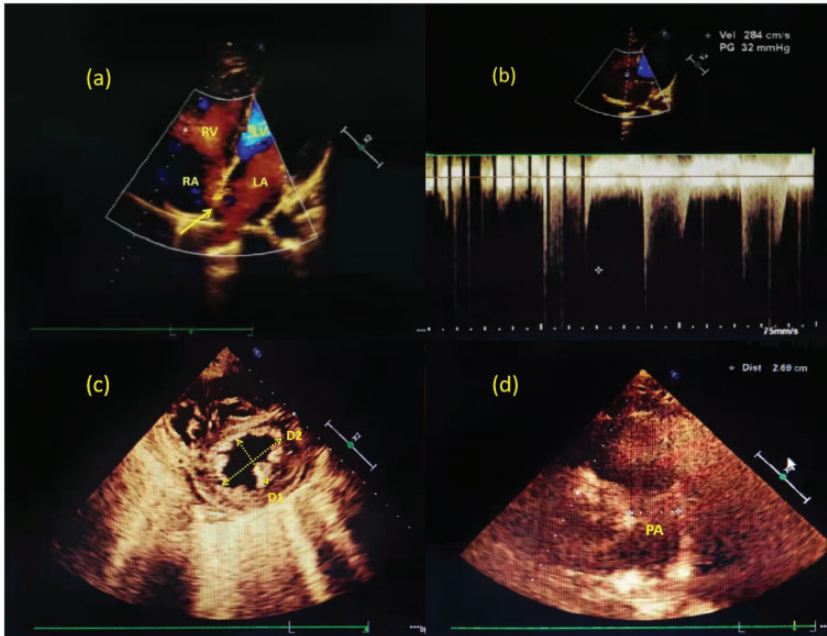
Transthoracic echocardiogram of a 43-year-old female patient, gravida 2, para 1, at 36 weeks of gestation, admitted in a stable condition following the diagnosis of placenta accreta for 1 month, demonstrated the following: (a) an atrial septal defect. The yellow arrow indicates that blood flowed through the opening in the septum (LA, left atrium; RA, right atrium; LV, left ventricle; RV, right ventricle); (b) estimated systolic pulmonary artery pressure; (c) an eccentricity index (EI) of 1.4 where $EI = D2/D1$ (D1, left ventricular diameter perpendicular to the septum; D2, left ventricular diameter parallel to the septum; (d) a dilated pulmonary artery (PA); The white dotted line represents the pulmonary artery diameter. The colour version of this figure is available at: <http://imr.sagepub.com>.
